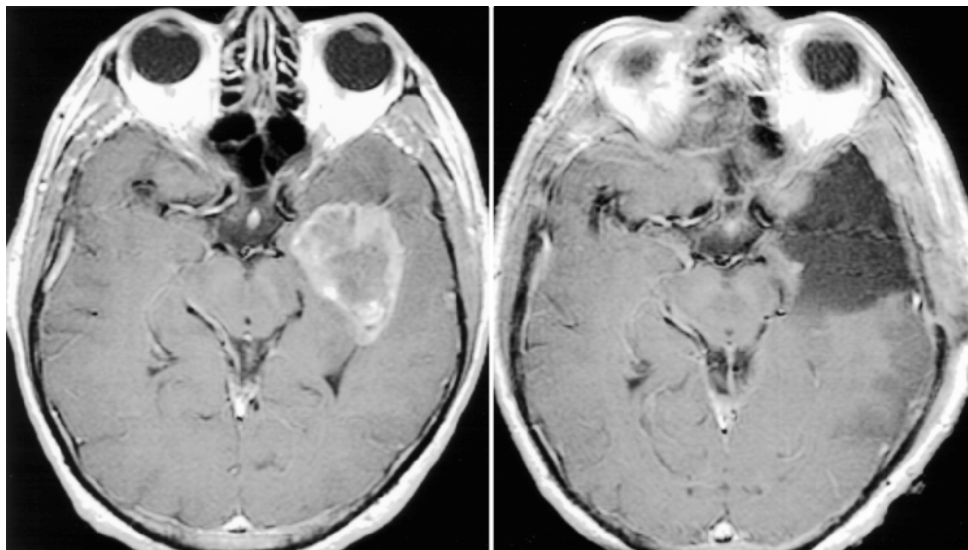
Contrast-enhanced axial T₁-weighted MR images obtained in a patient with GBM. Preoperative (*left*) and post-operative images (*right*) demonstrate a gross-total tumor resection.
